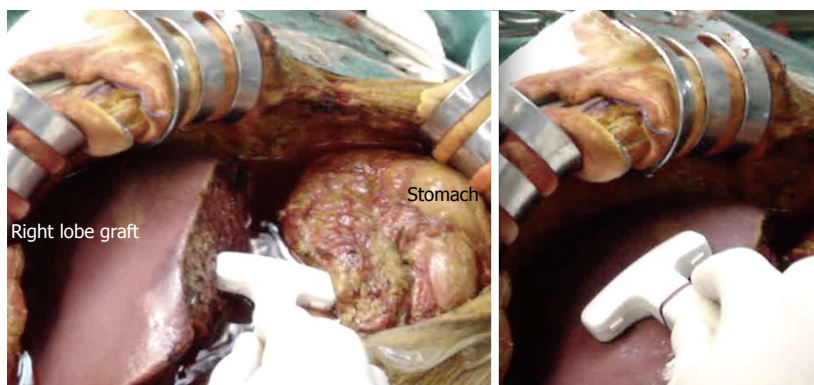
Photography showing the technique of intraoperative ultrasound. The upper abdominal cavity is filled with warm saline and a T-shaped 7-9 MHz linear transducer is applied at the graft hilum and graft surface.
